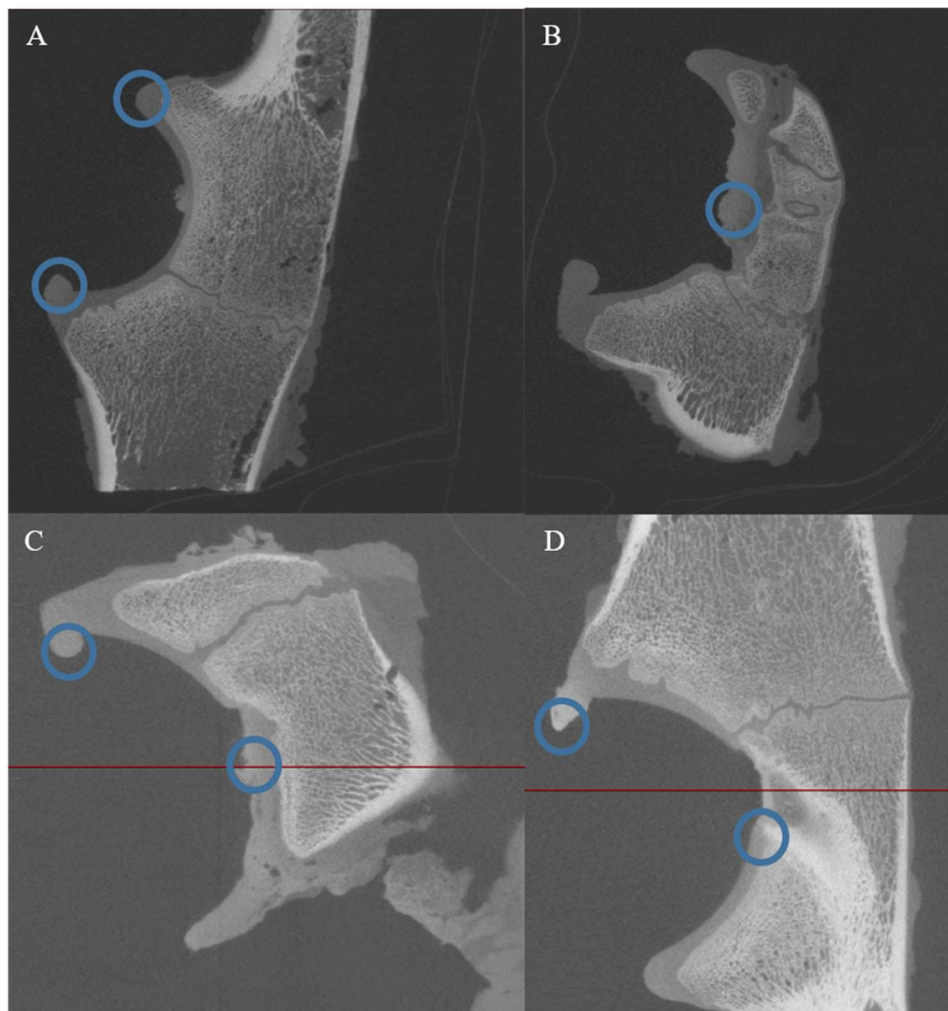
Highlight of the effect of the NaI solution in acetabular cartilage CT images at the coronal plane. A – NaI applied for 0.5 minute before wiped off. B – NaI applied for 3 minutes before wiped off. C – NaI applied for 5 minutes before wiped off. D – NaI was left on the acetabular cartilage. The effect of NaI solution on the cartilage were highlighted in the images.
